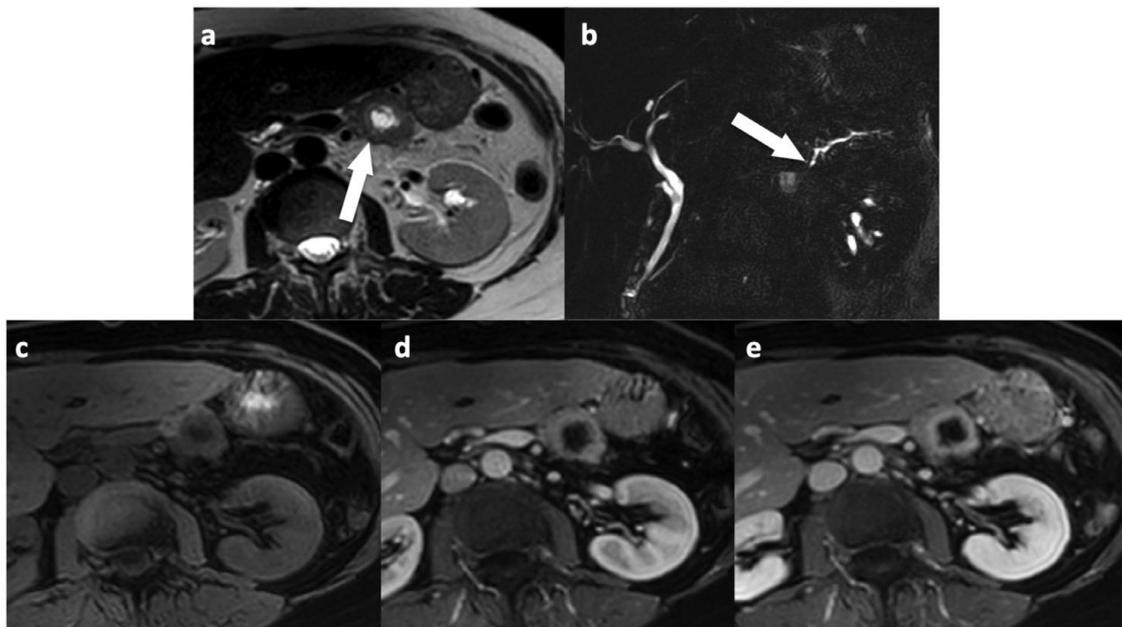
Adenosquamous adenocarcinoma in a 68-year-old female patient. Axial T2-weighted image (a) shows a lesion (arrow) located in the pancreatic body with central hyperintense portion. MR cholangiopancreatography (b) shows the upstream dilatation of the main pancreatic duct (arrow). The lesion is hypointense on precontrast (c) fat-suppressed T1 GRE image and shows a ring-like enhancing appearance on gadolinium-enhanced (d and e) fat-suppressed T1 GRE images obtained during portal venous (d) and delayed (3') phase (e). Diagnosis of adenosquamous adenocarcinoma was confirmed after resection.
